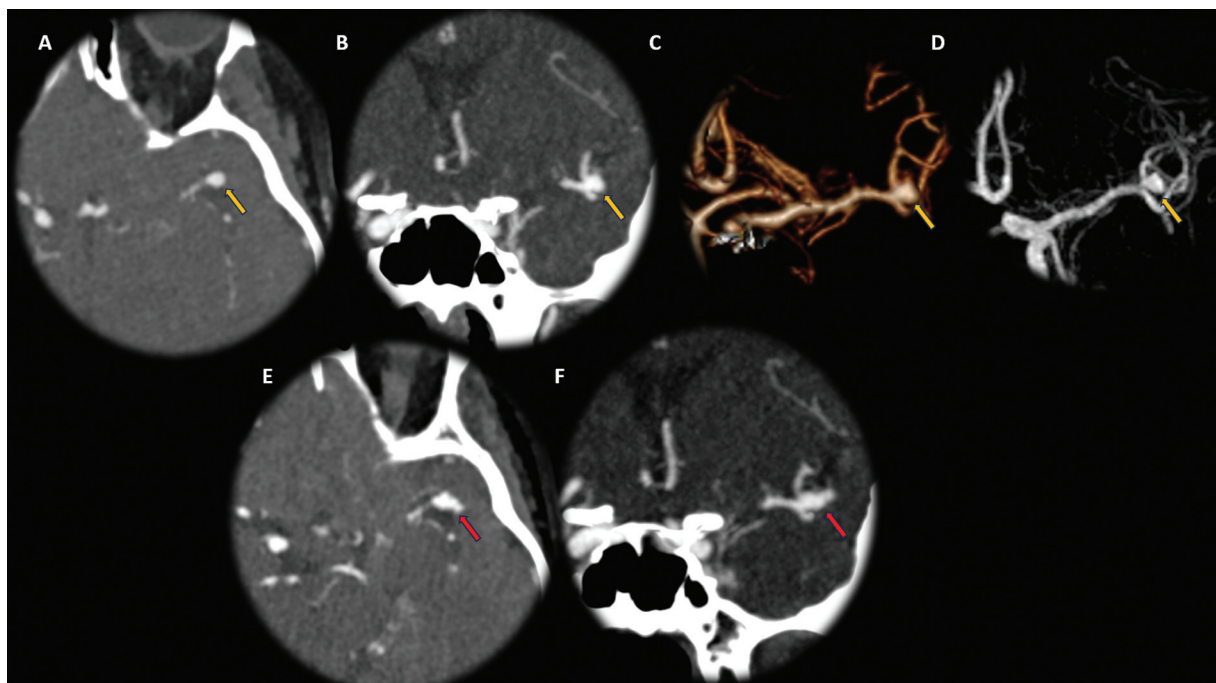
Previous head computed tomography angiography (CTA) (A–C) and head magnetic resonance angiography (MRA) (D); head CTA (E–F) follow-up on acute presentation. Increased size and new lobulation of the saccular left middle cerebral artery (MCA) aneurysm bifurcation (orange and red arrows).
